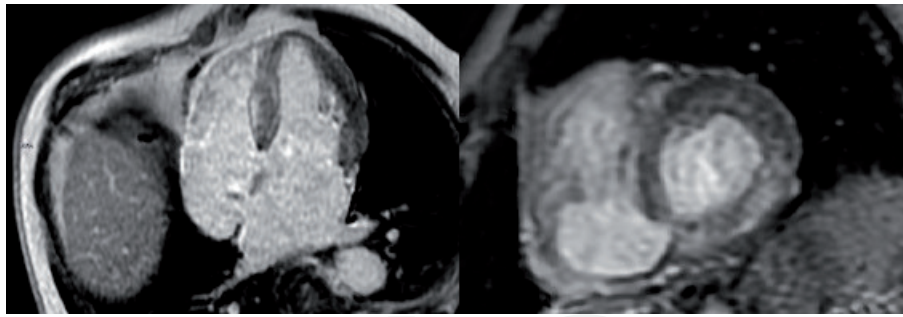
Cardiovascular magnetic resonance imaging of myocardial late gadolinium enhancement with pronounced septal and basal distribution.
